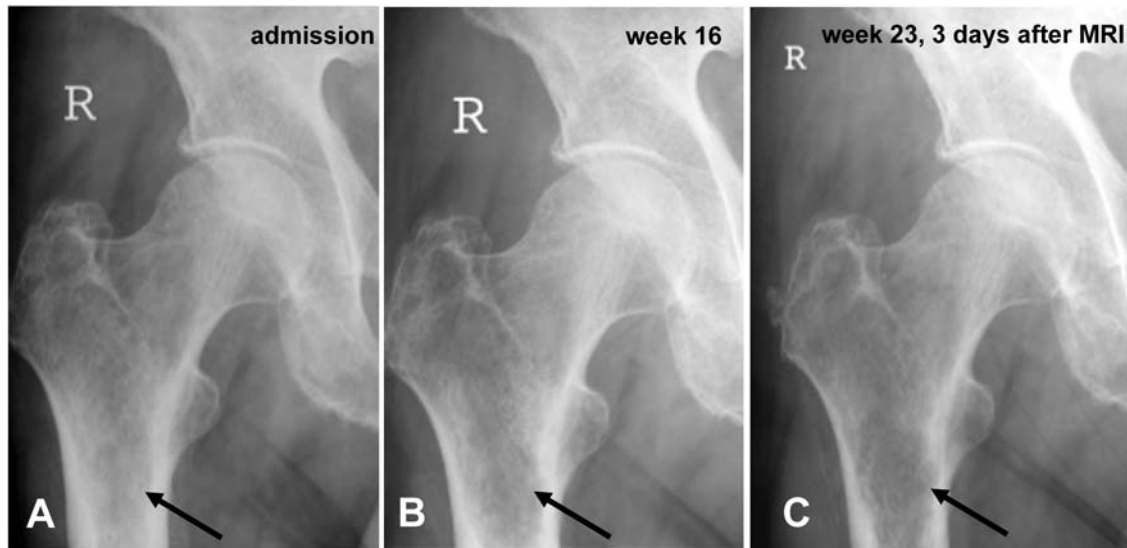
Radiological skeletal survey at initial presentation in 3/2007 (A), on recurrence of bone pain in 8/2007 (B) and after MRI (C). Osteolytic changes did not appear to be substantial at these times.
